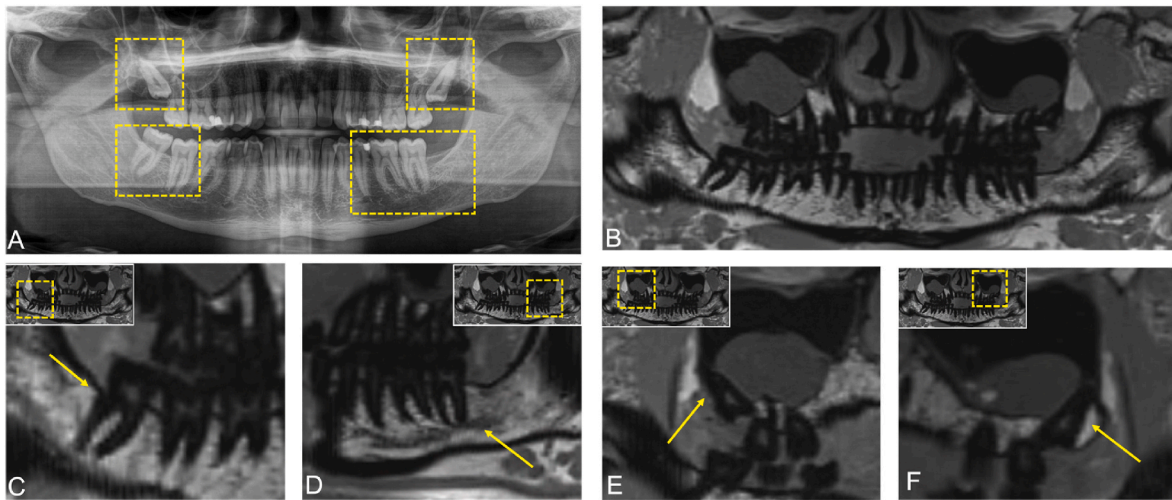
A. X-ray-based OPG (orthopantomogram) and B. overview image of an OPG-like MRI reconstruction (MR-OPG) from a volumetric interpolated breath-hold examination (T1-VIBE-Dixon) dataset. C. shows the third molar positional relationship in the third quadrant, while D. displays the situation in the fourth quadrant. E. and F. show the preoperative positional relationship of teeth 18 and 28.
